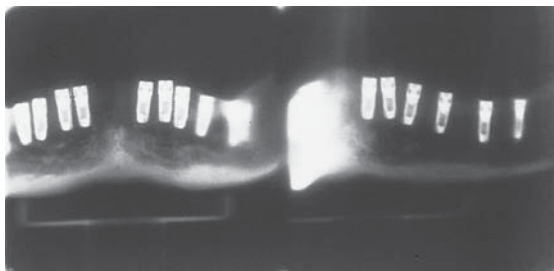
Radiographic result of the film tomography using the Tomax (sagittal cuts).
